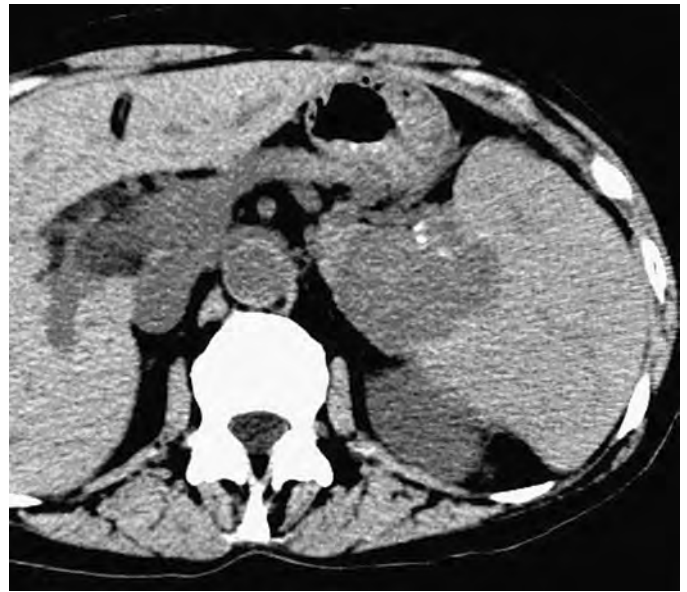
Splenic metastasis and peritoneal carcinomatosis from ovarian cancer. Noncontrast CT of the upper abdomen reveals an ill-defined mass containing a few small calcifications invading the hilum of the spleen.
